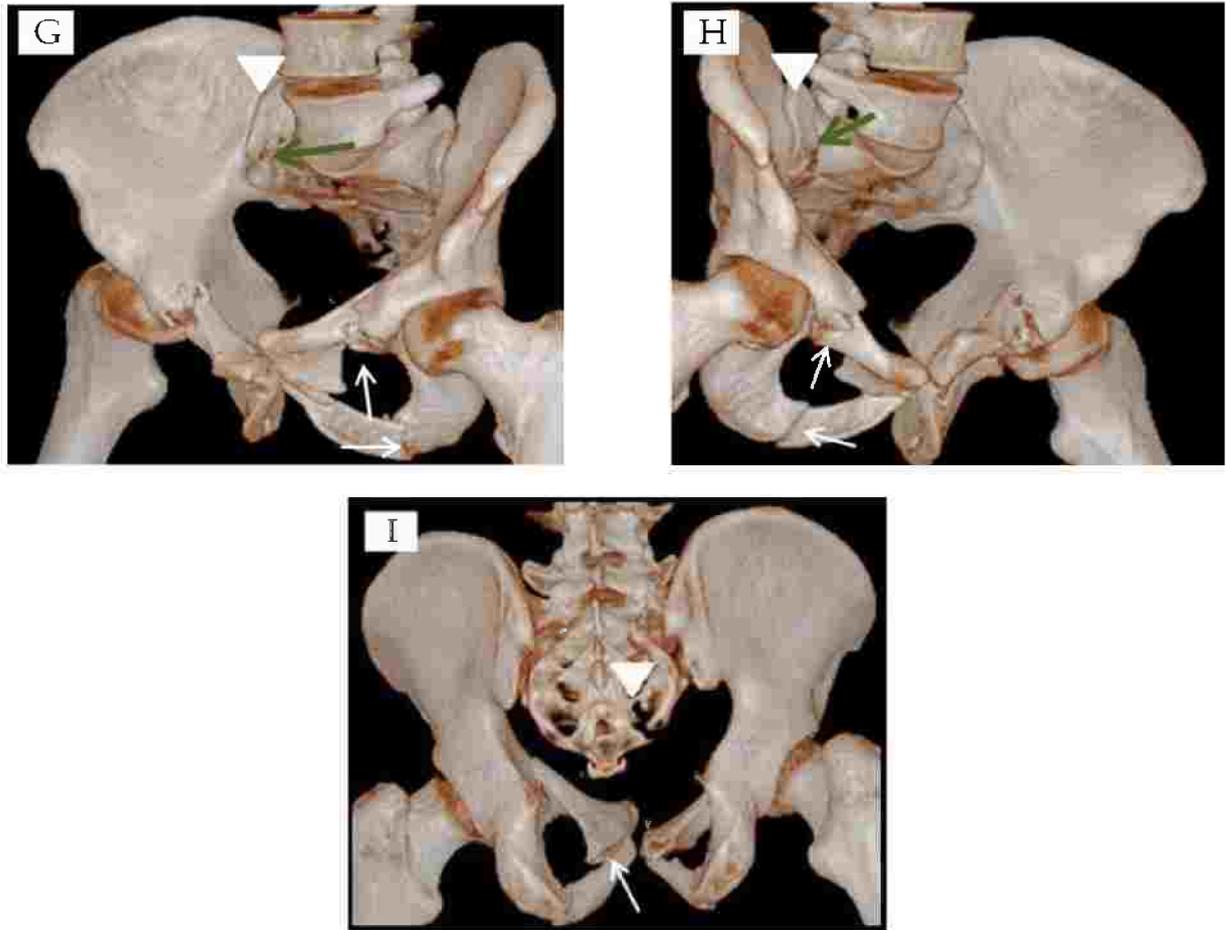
23 years old male with history of road traffic accident, (A) plain x ray anteriorposterior view, (B, C, D) axial CT, (E) coronal CT bone windows and (F,G,H, I) VR images they are showing right anterior SI joint diastasis (long arrow in B) with sacral fracture (arrow heads in A,B,E,F,G,H,I) .Both right and left superior and inferior pubic rami are fractured (short arrows in A,C,D,F,G,H,I) , with fragment (Green arrow in B,E,F,G,H). Conclusion: lateral compression pelvic fracture (Young classification), Type C1 (Tile classification).
